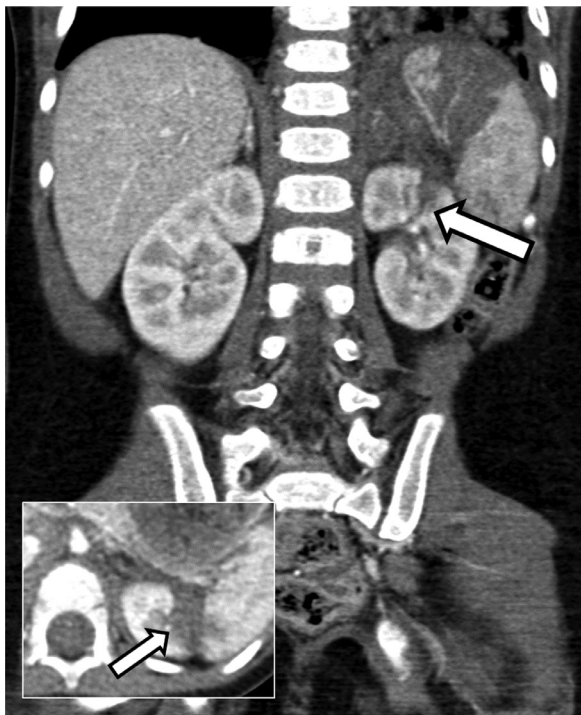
Contrast-enhanced polytrauma CT scan of the abdomen in coronal orientation in a toddler hit by a wooden truss. Apart from lung contusions and splenic lacerations, an upper pole kidney laceration (arrows) was noted. The laceration was deeper than 1 cm, regarded as grade III injury. The inlet shows an axial detail image of the renal laceration.
